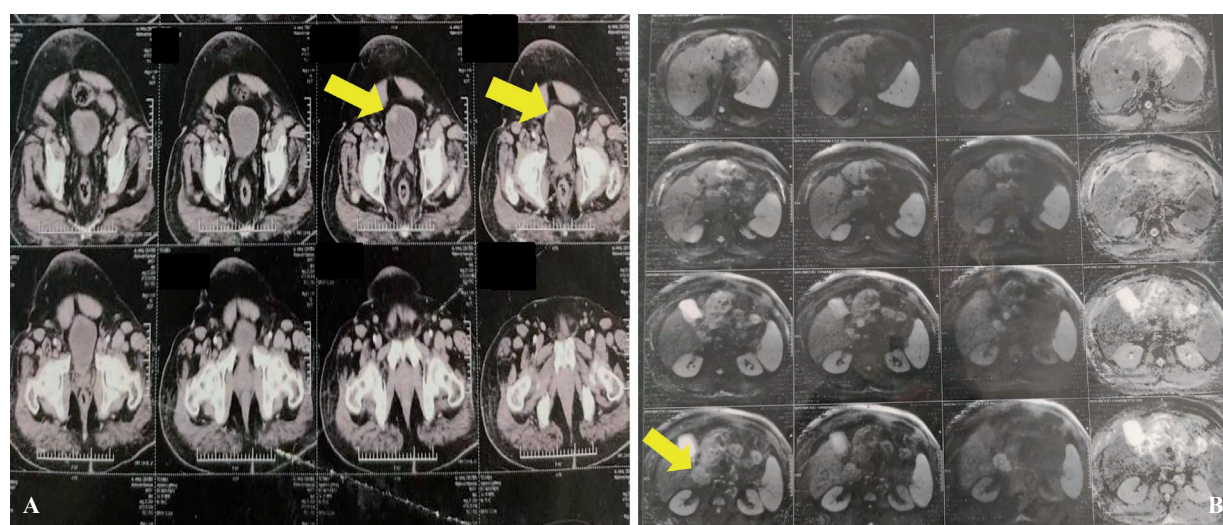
The imaging studies of case two documenting the presence of double primaries as the CT pelvi-abdomen dated September 2020 showing the urinary bladder gross (*right*) while the MRI pelvi-abdomen on March 2021 showing the porta-hepatis mass with malignant features (*left*). A, Multi-slice pelvi-abdomen axial view showing polypoid gross in the anteio-lateral aspect of the bladder. B, MRI pelvi-abdomen T2W1 with diffusion showing mass in the portahepatis 3*4 cm hyperintense with restricted diffusion and low ADC value. The liver is cirrhotic free of focal lesions with moderate splenomegaly and chronic calcular cholecystitis.
